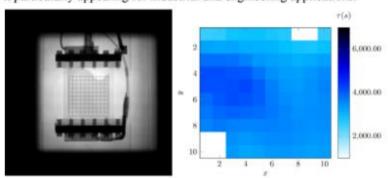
The first image shows a radiograph of the sample container loaded with HKUST-1 and liquid H<sub>2</sub>, a grid is overlaid to represent the different areas for which the conversion time (τ) is calculated. The second image shows the spatial distribution of τ, the outliers in the top right corner are due to the absence of the powder, those in the bottom left portray an area where hydrogen failed to reach.
